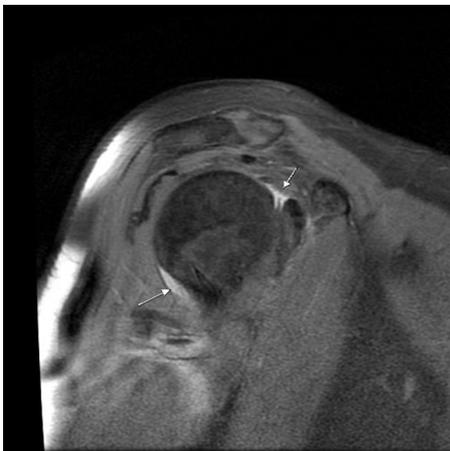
The MRI of right shoulder (PD FS).
